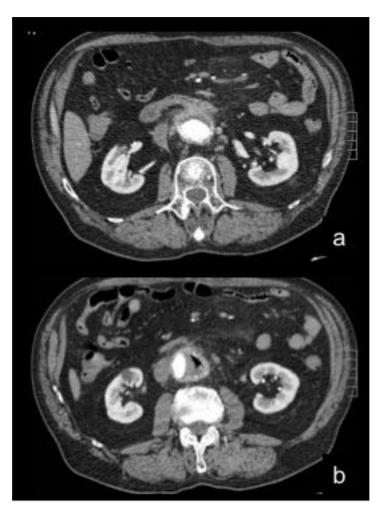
Contrast media abdomen CT in aortic phase SF, male, 71 yo: a case of infectious aortitis in a patient with abdominal aortic prosthesis.
